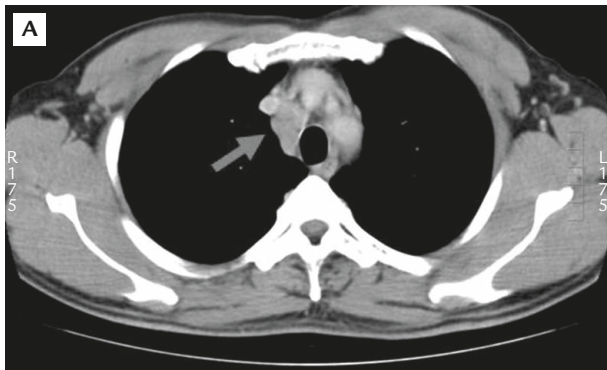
(A, B) Multiple enlarged mediastinal lymph nodes can be seen on chest computed tomography (arrows).
